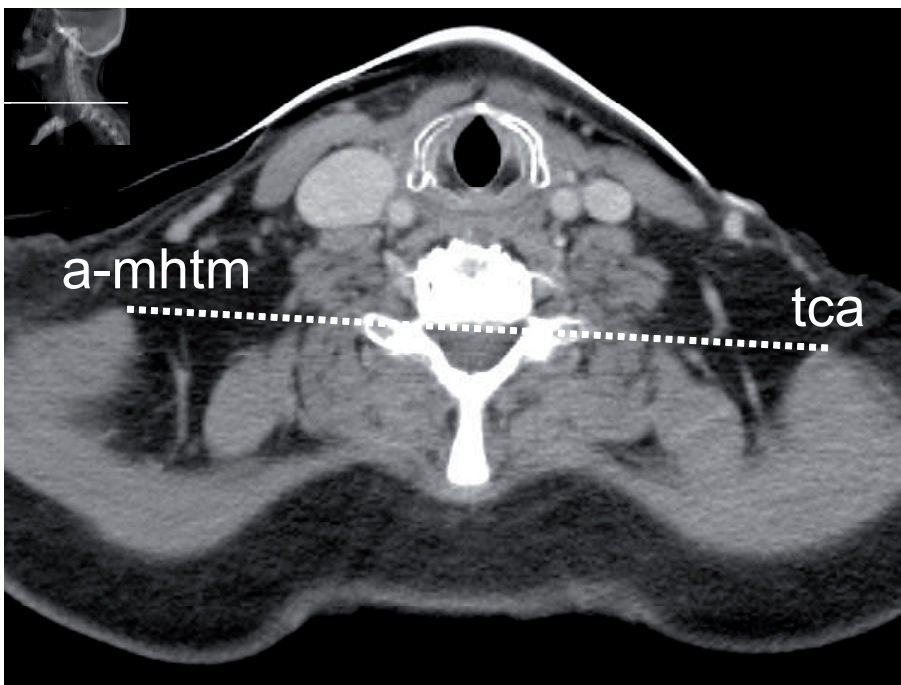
Caudal border level IV (CT-slice at the level of transverse cervical artery [tca]). Posterior border level IV and Vb (virtual line anterior medial heads of trapezius muscle [a-mhtm]).
